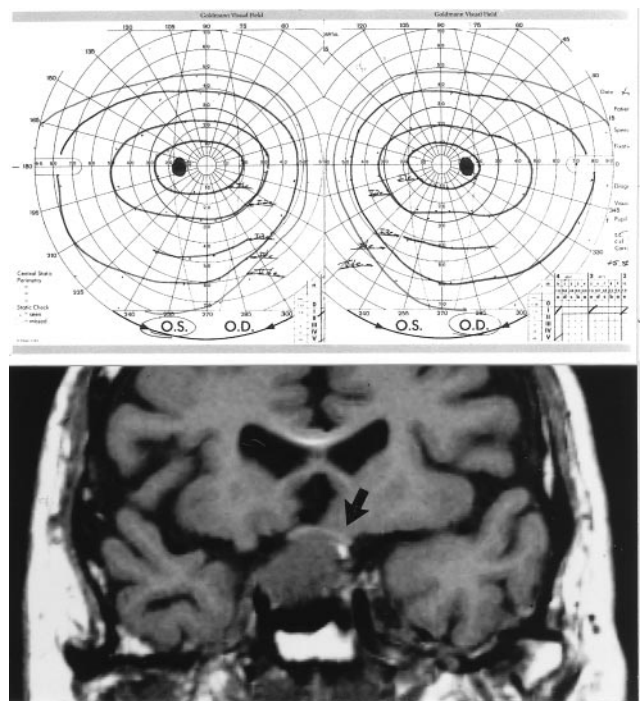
This 53-year-old man with a pituitary tumor and visual acuity of 20/20 in both eyes does not have any temporal visual field loss in either eye, despite the presence of considerably greater chiasm compression than existed in our case report. (Top) The Goldmann test targets (I1e, I2e, I3e) used to plot his visual field were the same targets that identified a central scotoma and contralateral superotemporal depression in our case report (see Figure 1 in our paper). (Bottom) Notice how the chiasm (black arrow) is thin, angulated over the dome of the tumor, and pinned against the gyrus rectus from above, which are radiographic signs indicative of much greater compression than existed in our Case Report (see Figure 2 in our paper).
